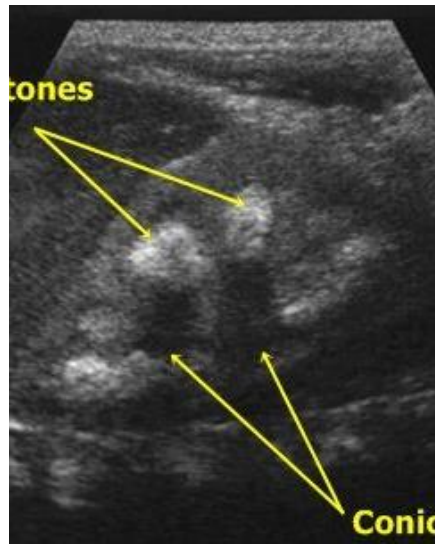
Kidney stone image using ultrasound
